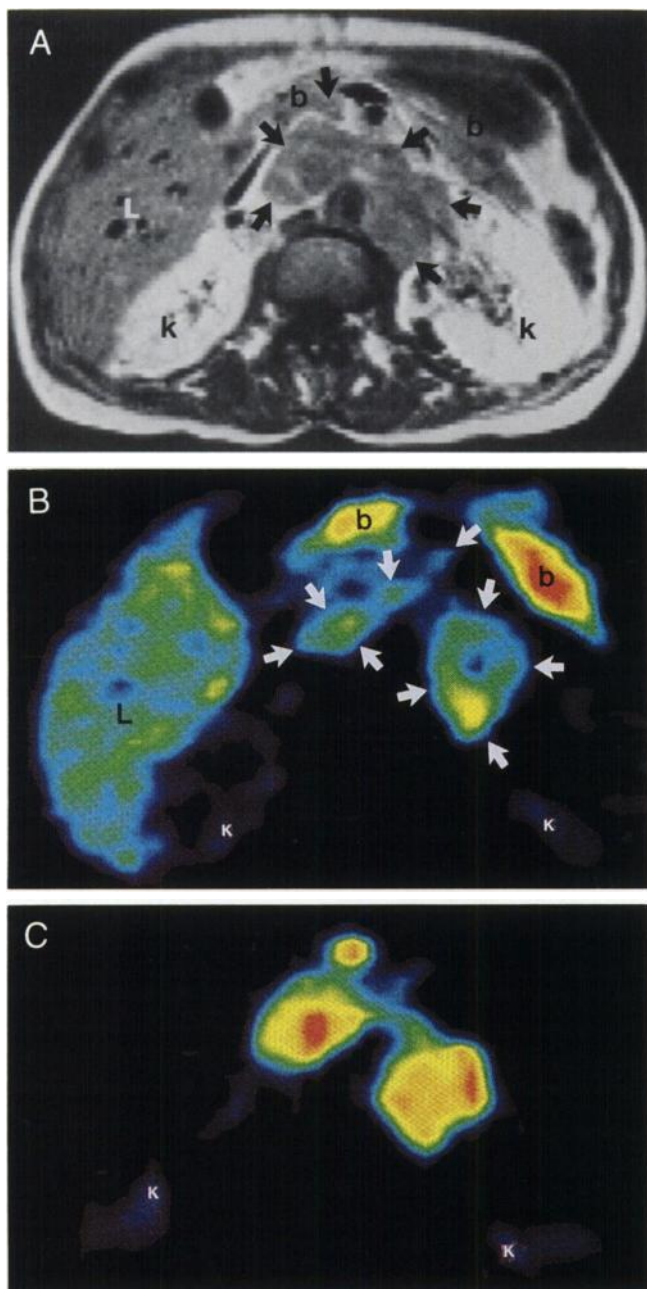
Axial MRI and PET images of the abdomen at corresponding levels in a patient with high-grade NHL. (A) MRI T1-weighted image obtained after intravenous injection of gadolinium contrast depicts a large central tumor (arrows). L = liver, k = kidney, b = bowel. (B) PET ^{11}C methionine SUV image visualizes tracer uptake in the tumor (arrows), liver (L), kidneys (k) and bowel (b). Red and yellow colors correspond to high tracer uptake. (C) PET ^{18}F FDG SUV image visualizes tracer uptake in the tumor and kidneys (k). Red and yellow colors correspond to high tracer uptake.
